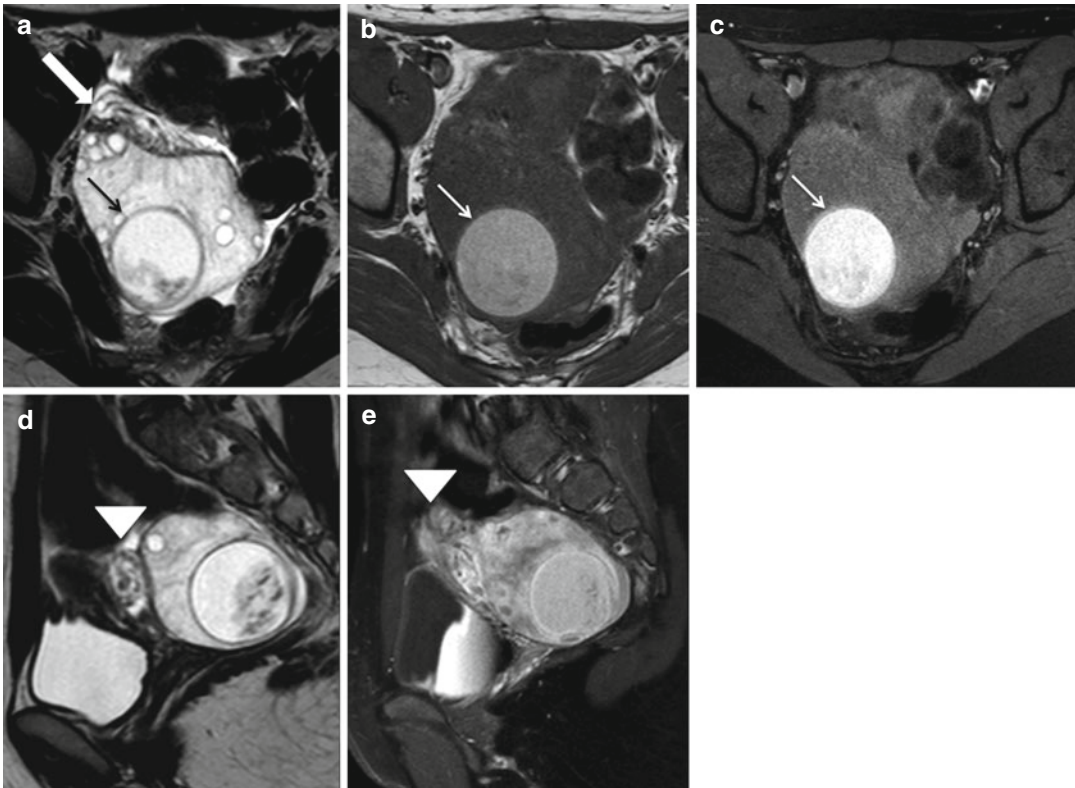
A 14-year-old girl with a twisted right ovary and hemorrhagic luteal cyst. (a, d) T2-weighted coronal and sagittal images show an enlarged ovary with multiple follicles peripherally placed and a large heterogenous cyst (*black arrow*). The associated twisted pedicle is also
